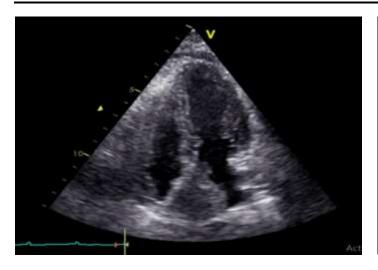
Transthoracic echocardiography (TTE) images showing a mass attached to the lateral wall of the mobile left atrium measuring 40x14mm prolapsing the mitral valve and the base of the left ventricle during non-obstructive diastole, with a second echogenic mass measuring 06x05mm adherent to the atrial side of the large mitral valve, all suggesting a secondary localization of mediastinal sarcoma.
